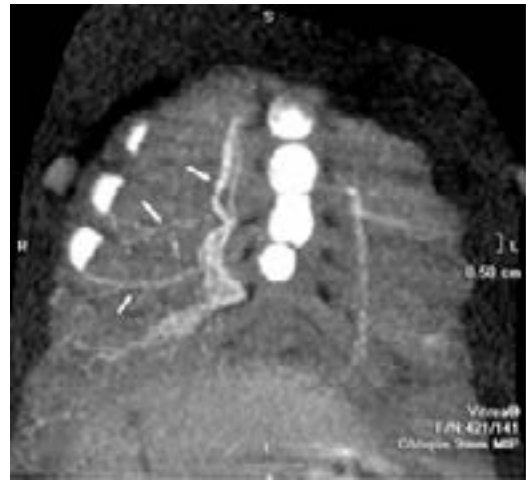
Frontal CT scan reconstruction shows an unusual collateral vessel (arrows) from the right subclavian artery penetrating the right hilum.
